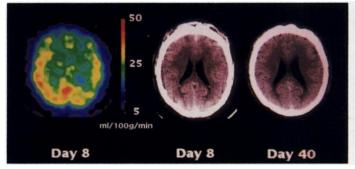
In Patient 7, the rCBF image (left) showed hypoperfusion in the territories of the bilateral anterior cerebral artery and left middle cerebral artery on Day 8, when motor aphasia was manifest. CT scan revealed no evidence of infarction (center). rCBF was 23 ml/100 g/min in the territories of vasospastic arteries. No brain infarction was found on the follow-up CT (right).
